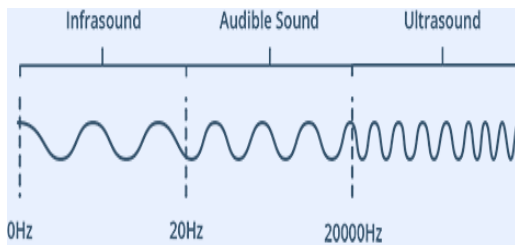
Ultrasound wavelength
